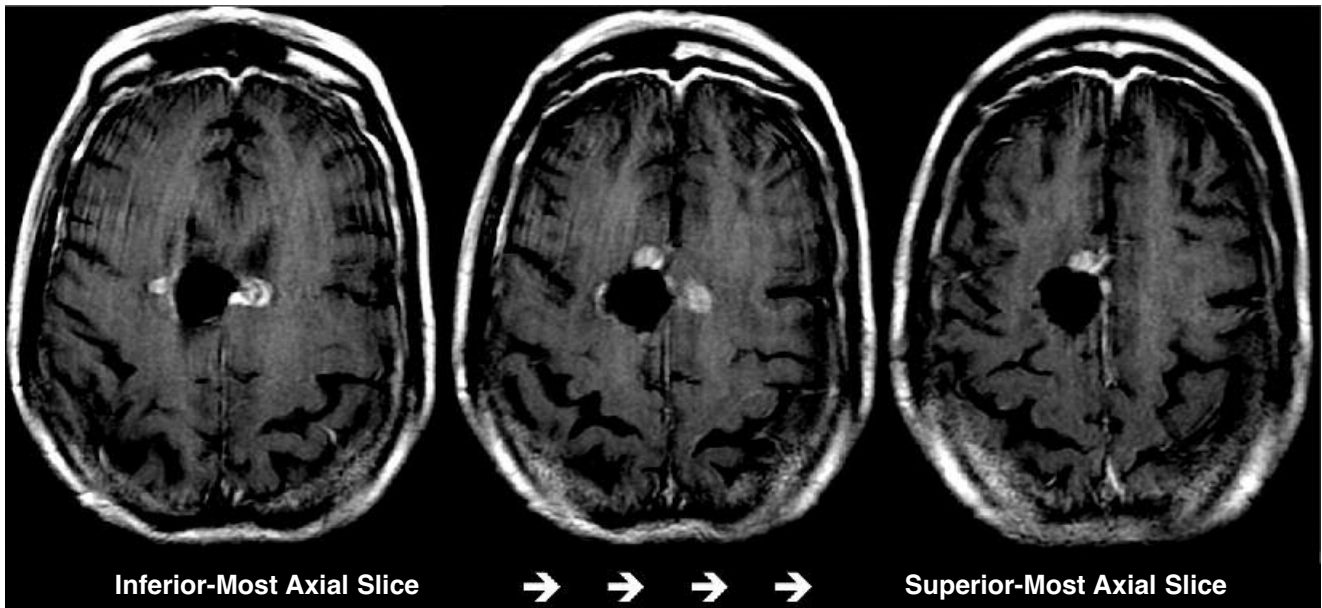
T1-weighted axial post-contrast MRI demonstrating tumor nodules at the initial diagnosis of recurrence. Three predominant nodules are seen anterior and lateral to the resection cavity. Images shown are consecutive from inferior to superior; 6-mm slice thickness.
